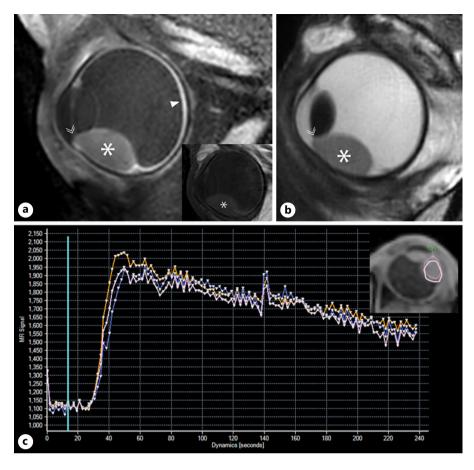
MRI of UM. Contrast enhanced T1weighted (a) and T2-weighted MR-image of a UM-containing eye (b), showing an enhancing UM (asterix) and choroid (arrowhead) compared to the native T1weighted image (inset). Note that the UM has grown through the iris (double arrow). c PWI showing a rapid uptake of the gadolinium contrast agent, followed by a gradual decrease. This so-called wash-out curve is seen in two-thirds of UM. PWI, perfusion-weighted imaging.
